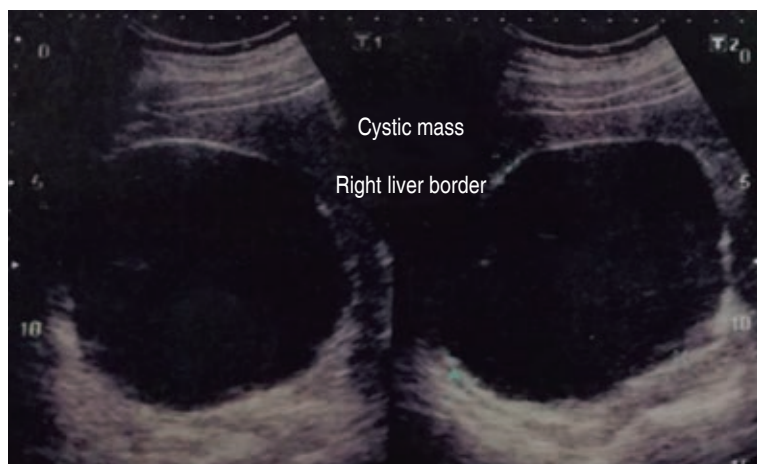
Hepatic ultrasound with a rounded, thin-walled, well-defined anechoic image.
